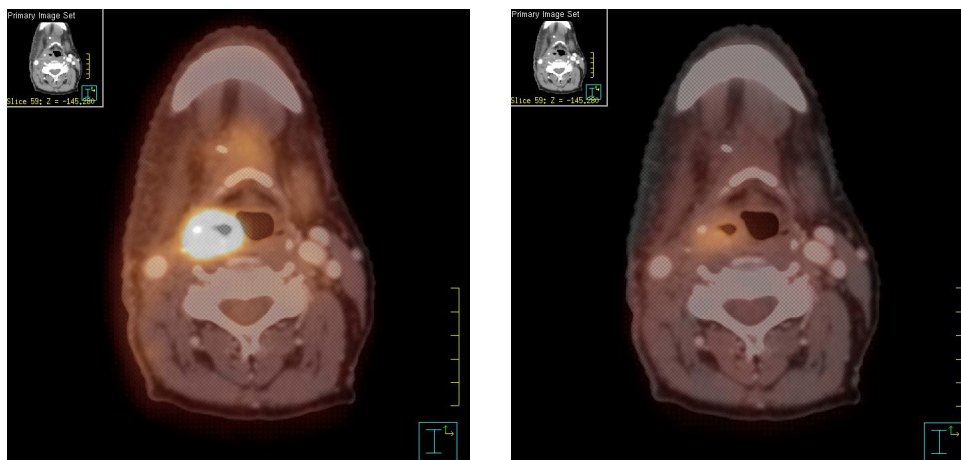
Transverse slices of pre- and per-treatment FDG-PET images registered to the pre-treatment CT of a patient included in the Phase I clinical trial on adaptive FDG-PET guided BCRT at GUH.
